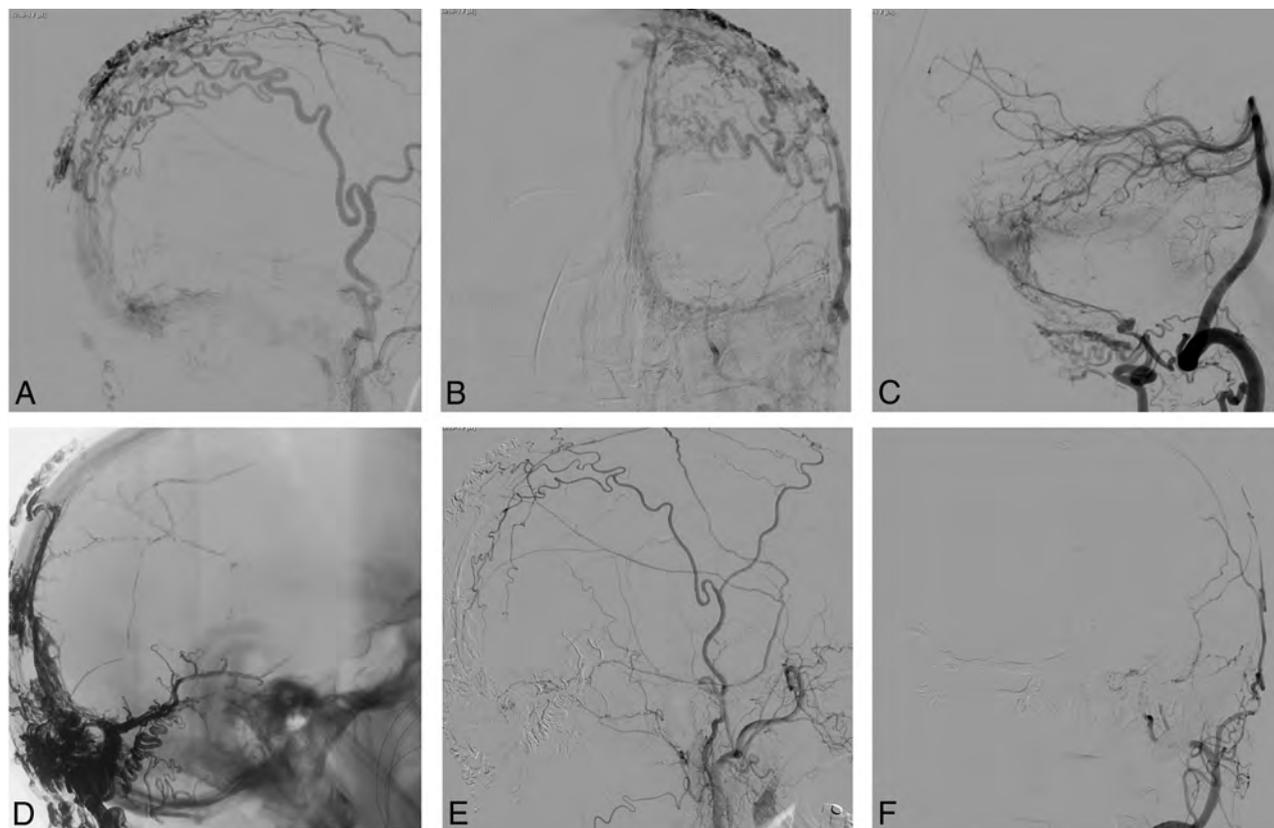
Lateral (A) and anteroposterior (B) projections of a pretherapeutic left external carotid artery DSA showing a complex fistula of the posterior third of the superior sagittal sinus in a patient with signs of intracranial hypertension. Lateral projection (C) of the left vertebral artery injection in the same patient shows multiple fistulous points on the transverse and sigmoid sinuses. D, A lateral skull x-ray with the important cast of Onyx used to treat the fistulas. Posttherapeutic lateral (E) and anteroposterior (F) projections of the left external carotid artery injection.
